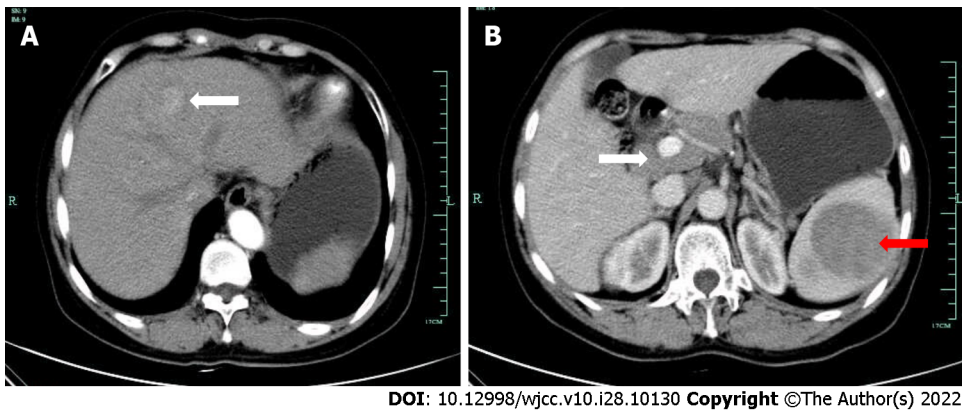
Patient's enhanced computed tomography images. A: Enhanced computed tomography examination showed a mass with a diameter of approximately 2.6 cm on the left liver lobe on January 13, 2015; B: The splenic portal phase showed multiple circular low-density shadow areas with a maximum diameter of approximately 7.6 cm (red arrow); multiple enlarged lymph nodes were detected around the liver hilum and retroperitoneum with partial fusion conglomeration (white arrow).
